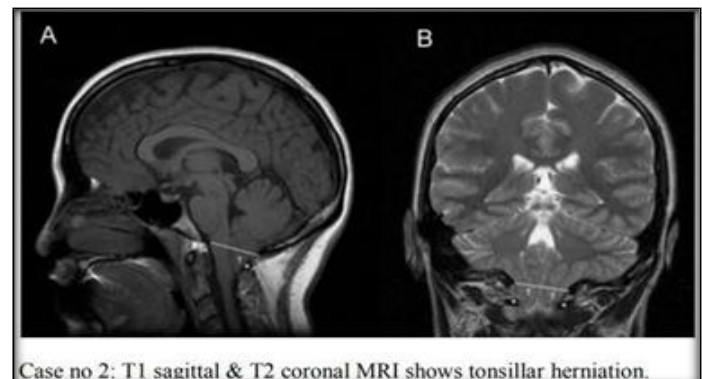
Case No. 2 — T1 sagittal (A) and T2 coronal (B) MRI demonstrating tonsillar herniation consistent with Arnold-Chiari malformation Type 1.
